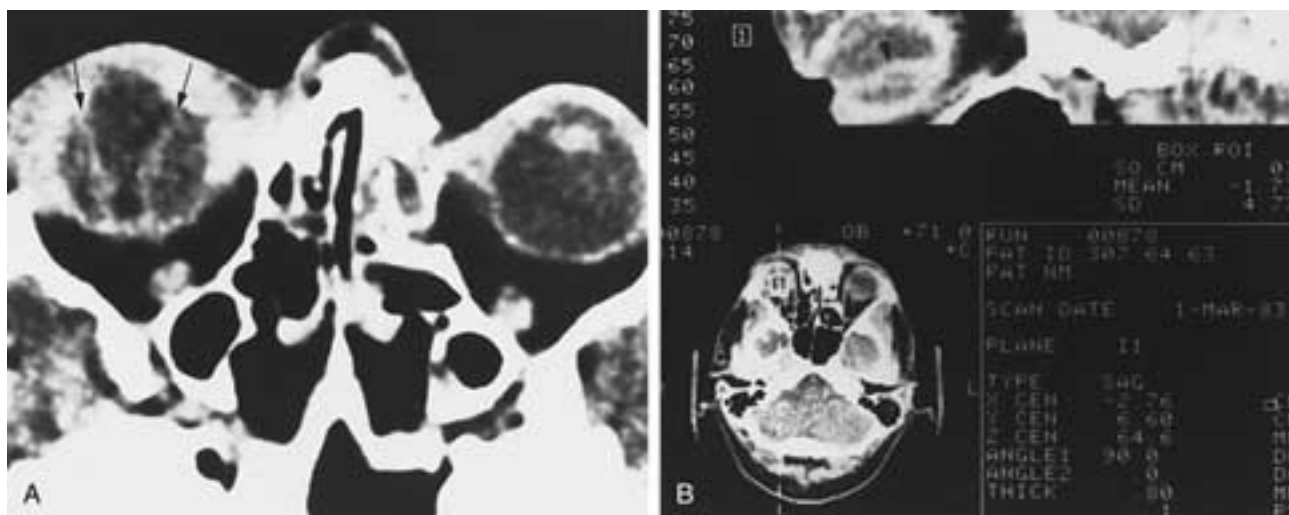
Serous choroidal detachment. A, Axial CT scan. B, Reformatted sagittal CT image. Scans show detached choroid (arrows and arrowhead). The suprachoroidal space is isodense to vitreous compatible with serous fluid.
